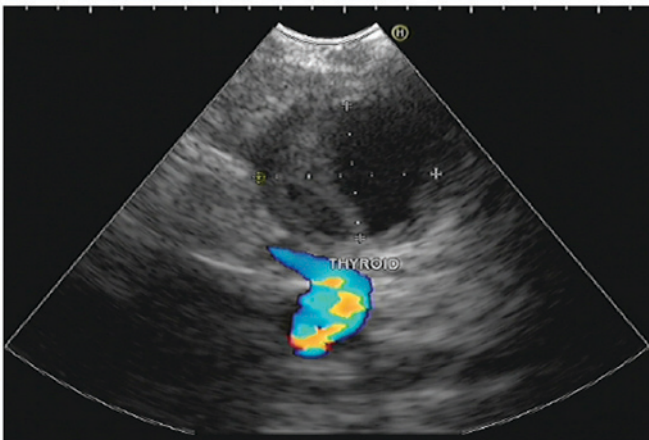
Endobronchial ultrasound with color doppler revealed an oval lesion in the right lobe of the thyroid.
